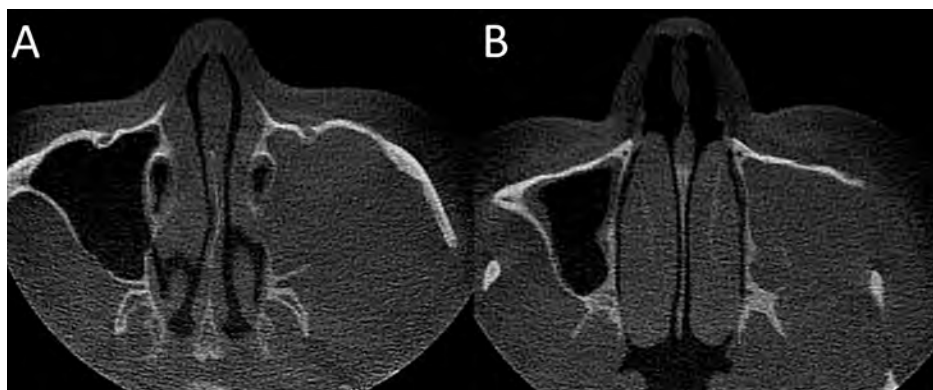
CBCT Axial Slices of the patient show lateral and posterior wall destruction at the left maxillary sinus.
